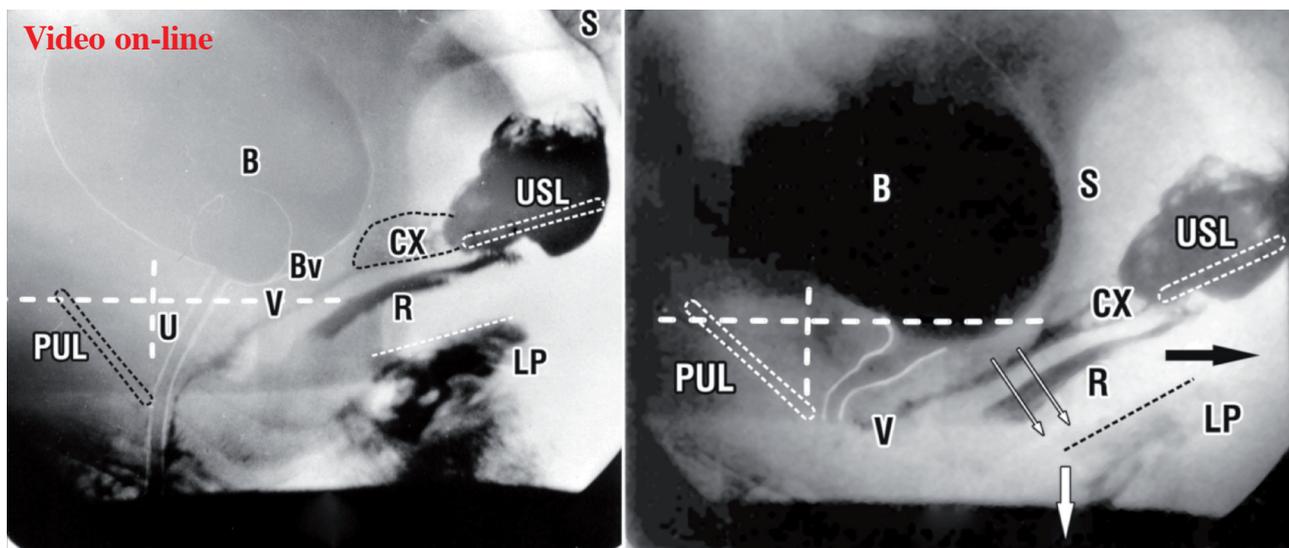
Normal patient - xrays at rest (left) and during micturition (right), samepatient in sitting position At rest, slow twitch contractions angulate bladder (B), urethra (U), vagina (V) and rectum (R) around the insertion of the pubourethral ligament (PUL) at midurethra. 10ml radioopaque material has been injected into the levator plate (LP) vagina and rectum. Vertical and horizontal broken lines indicate bony co-ordinates. During micturition (right figure), the urethra has moved backwards from the vertical co-ordinate, suggesting relaxation of the forward vector. Vagina and rectum appear to have been stretched backwards by a backward vector (black arrow). The anterior part of LP has been angulated downwards apparently by the downward vector (white arrow) acting against the cervix (CX)/uterosacral ligament (USL) complex. The backward/downward vectors (thin diagonal arrows) create a diagonal vector force which seems to be pulling open the posterior urethral wall. S=sacrum. Micturition video in the journal online.
